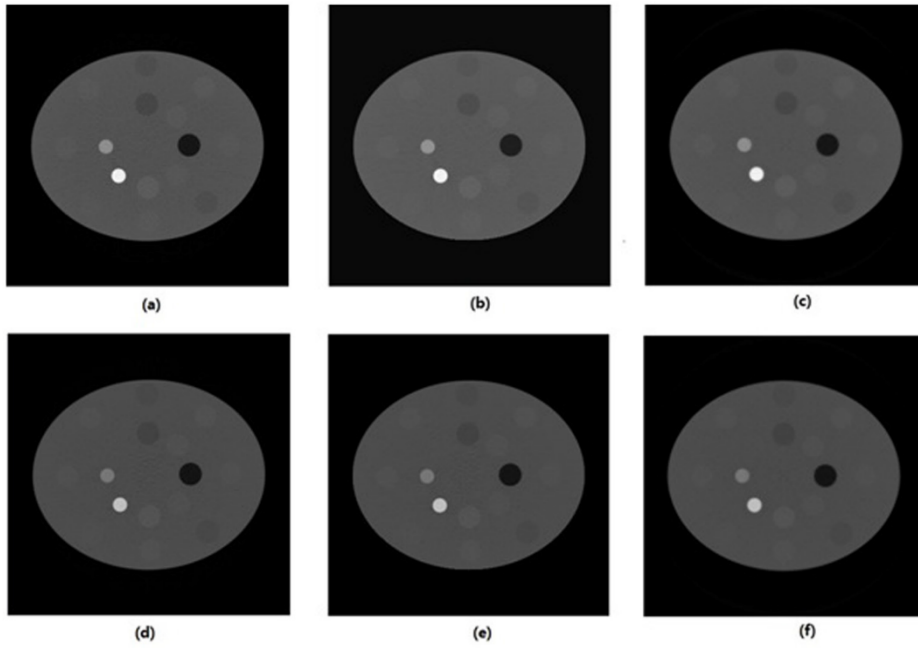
X-ray CT images at 90 kVp (top row) and 140 kVp (bottom row) reconstructed by (a) and (d) FBP, (b) and (e) FBP-TVM, and (c) and (f) TVS-DROP. The pixel value viewing range is 0.00–0.67.
